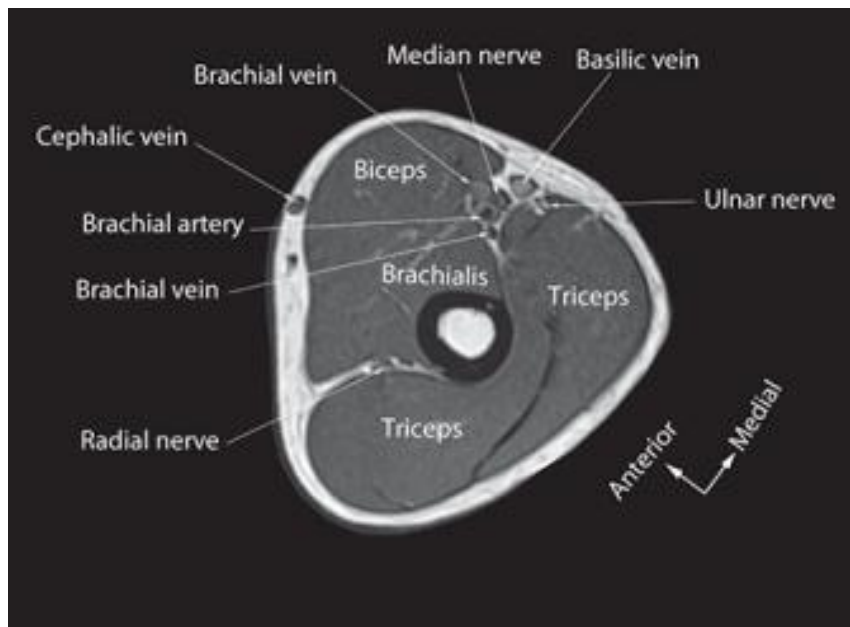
Axial CT cut at the distal third of the arm
